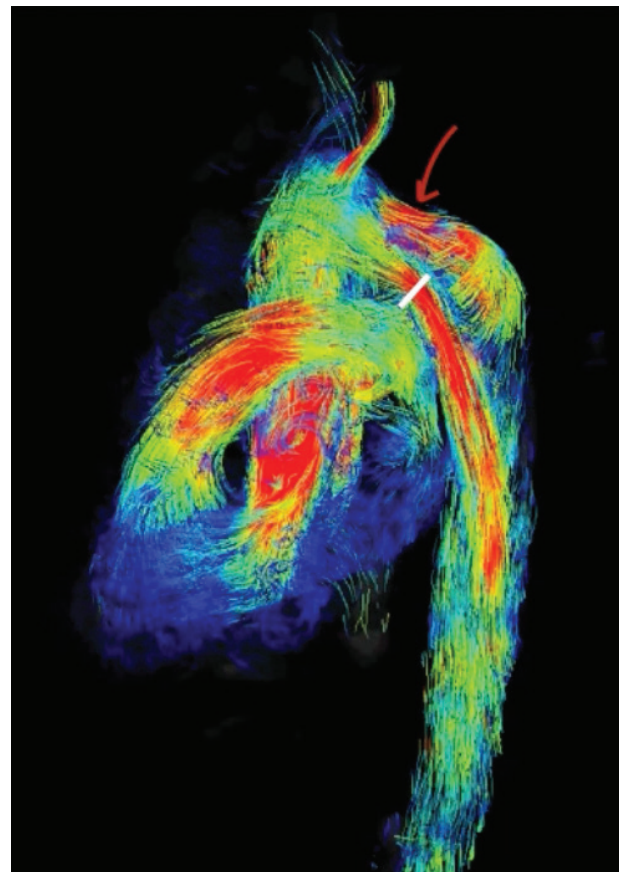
4D MRI of acute TBAD showing systolic antegrade flow through large primary entry tear in aortic zone 3 (red arrow) and high-energy flow through compressed diameter TL just distal to the entry tear (white line).
